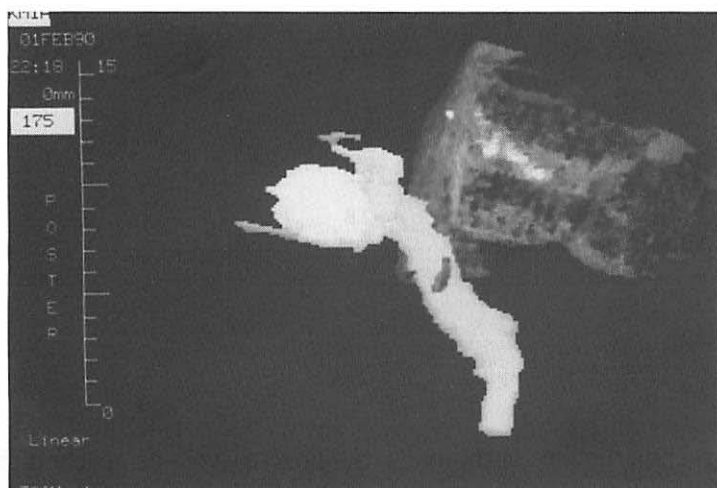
Transparency display and block display are combined. The right lobe of the liver is cut off, the left lobe is displayed as block with CT values added to the surface. Tumor and portal vein with branches are added as distinct objects.
